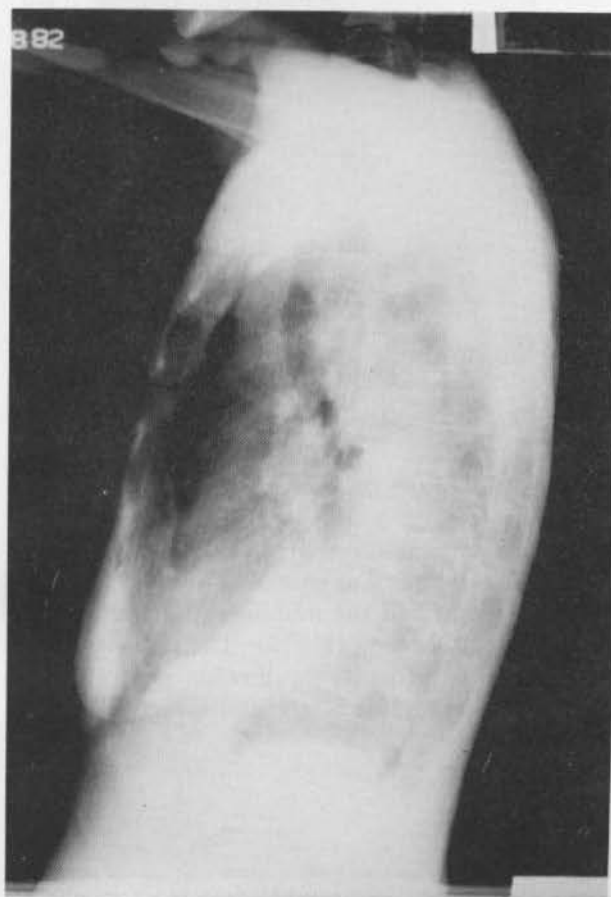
Lateral Chest roentgenogram
